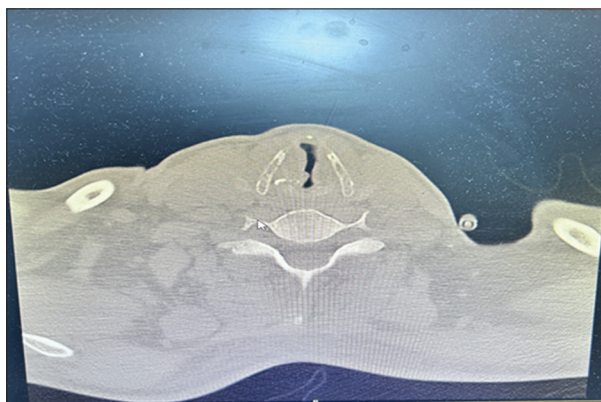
Left vocal cord palsy during valsalva-computed tomography
